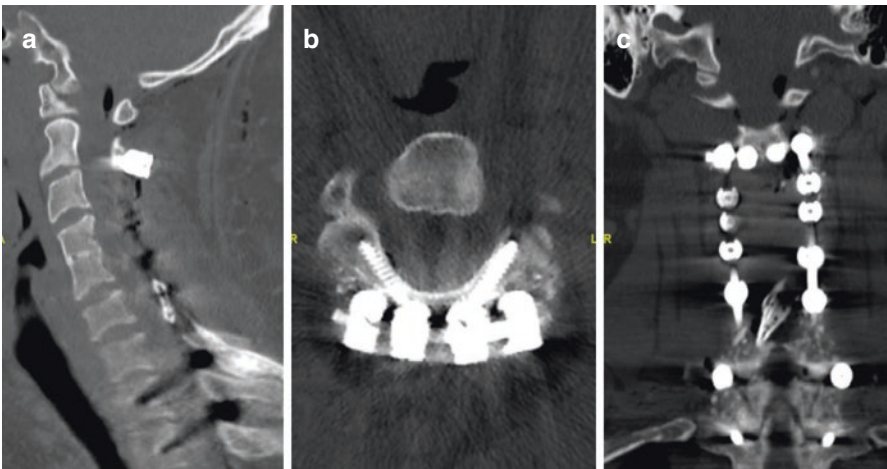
Post-operative CT scan following cervical spine tumor resection and C2-T2 instrumentation. Sagittal (a) and axial (b) and coronal (c) demonstrate extent of bony removal and hardware placement
